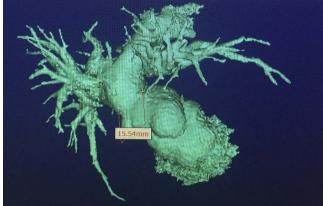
Segmented Computed Tomography (CT) imaging dataset with 3-dimensional rendering of model.
